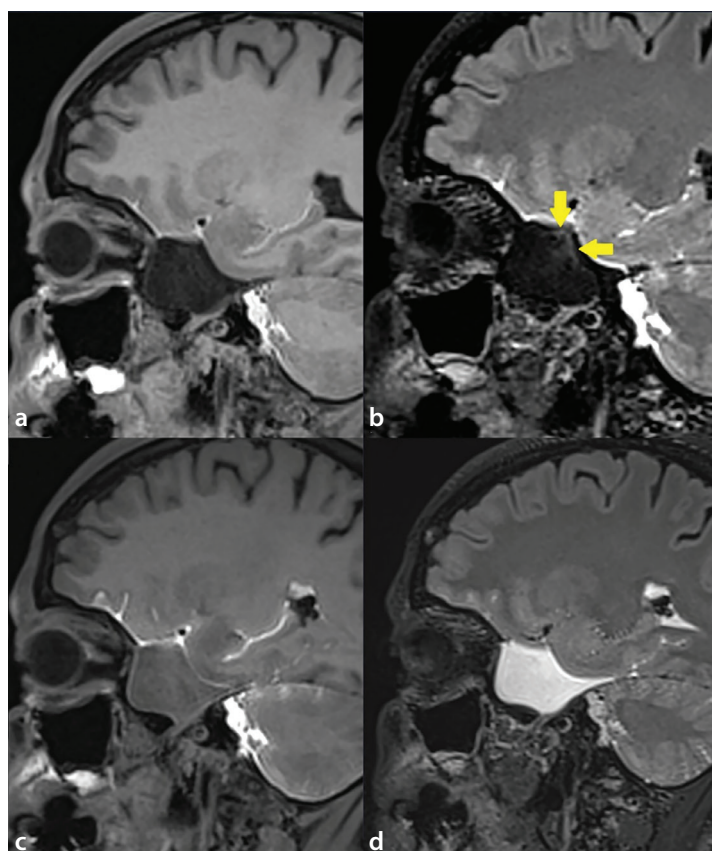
Example of a middle cranial fossa IC-AC. The EP-T1 image (a) shows no visible opacification. The EP-FLAIR image (b) demonstrates a faint focal signal increase in the posterosuperior peripheral portion of the cyst (yellow arrows), consistent with grade 1 opacification. The LP-T1 image (c) shows mild opacification involving part of the cyst (grade 2). The LP-FLAIR image (d) demonstrates marked signal increase with near-complete opacification (grade 4). AC, arachnoid cyst; IC, incompletely communicating; EP, early phase; EP, early phase; FLAIR, fluid-attenuated inversion recovery; LP, late phase.
